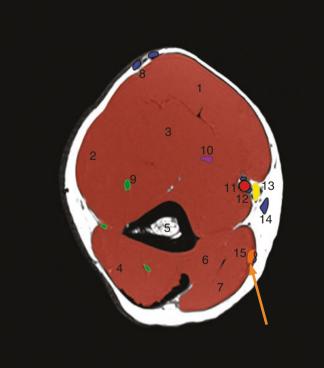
MRI scans at the proximal third of the arm through the ulnar nerve
